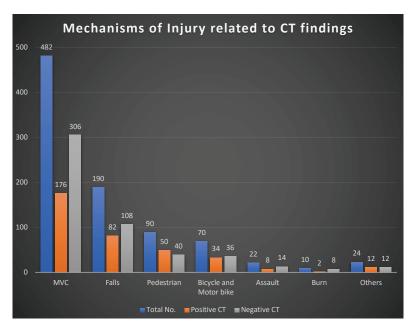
Mechanisms of Injury related to CT findings
